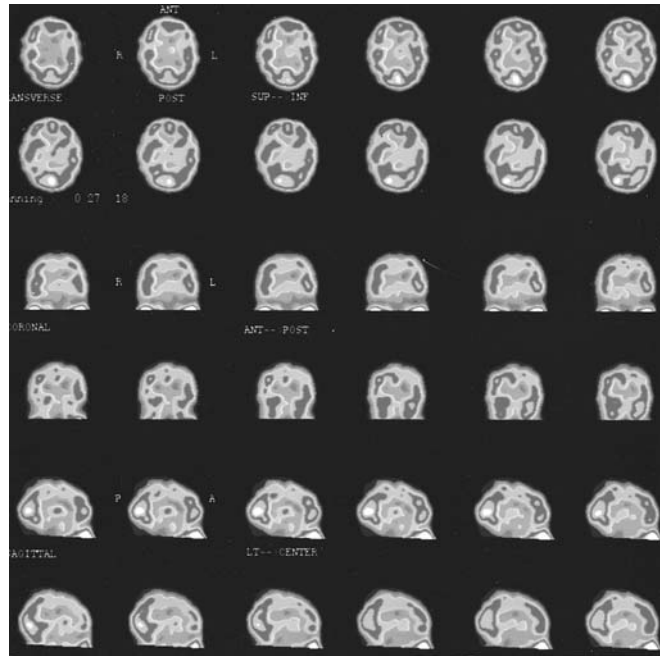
Brain SPECT of an SLE patient showing the multiple-focal pattern of hypoperfusion
